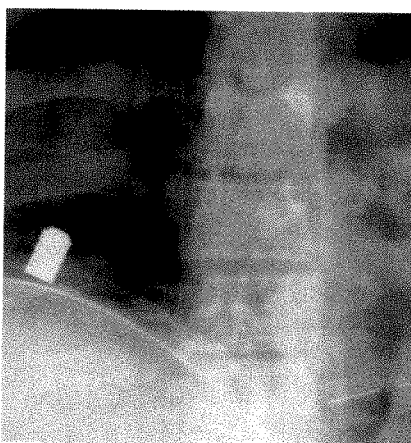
Close-up chest radiograph at diaphragm after handgun injury shows undeformed lead bullet with flat head (wad cutter) and multiple circumferential cannalures diagnostic of a nonjacketed bullet.
